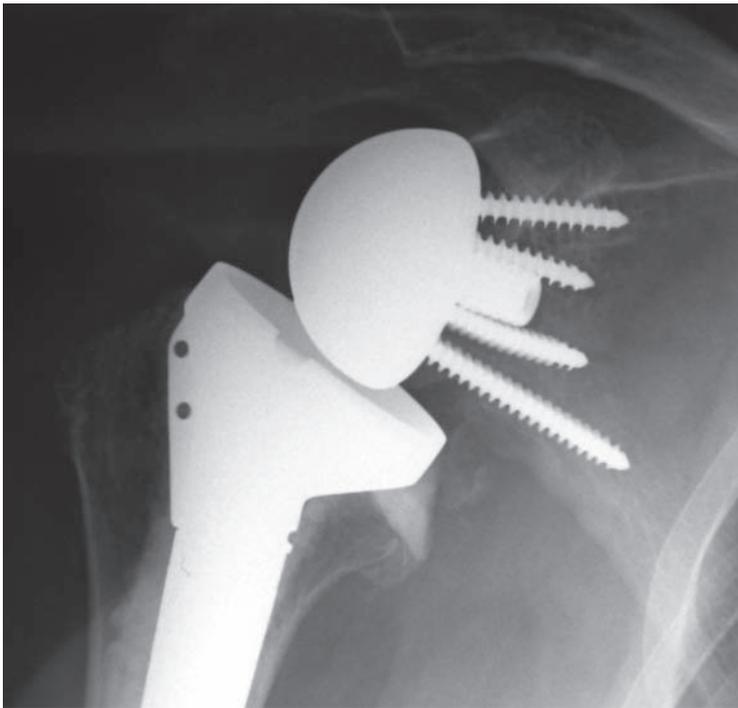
Postoperative radiograph of reverse prosthesis.
